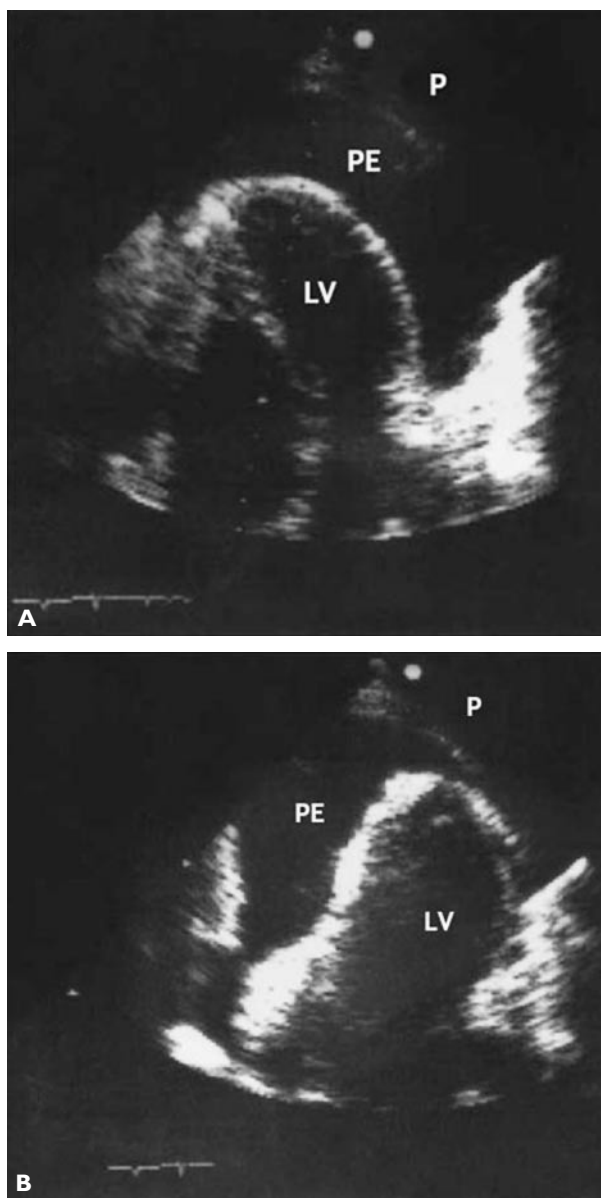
Swinging of the heart with a large pericardial effusion (PE) causing electrical alternation and consequent tamponade. Apical 4-chamber 2-dimensional echocardiograms show the extremes of oscillation and the resultant effect on the QRS complex. (A) The heart swings to the right, and lead II shows a small QRS complex. (B) The heart swings to the left, and the QRS complex is larger. LV = left ventricle; P = pericardium. (Adapted with permission from Spodick DH. Acute cardiac tamponade. *N Engl J Med* 2003;349:687. Copyright © 2003 Massachusetts Medical Society. All rights reserved.)
